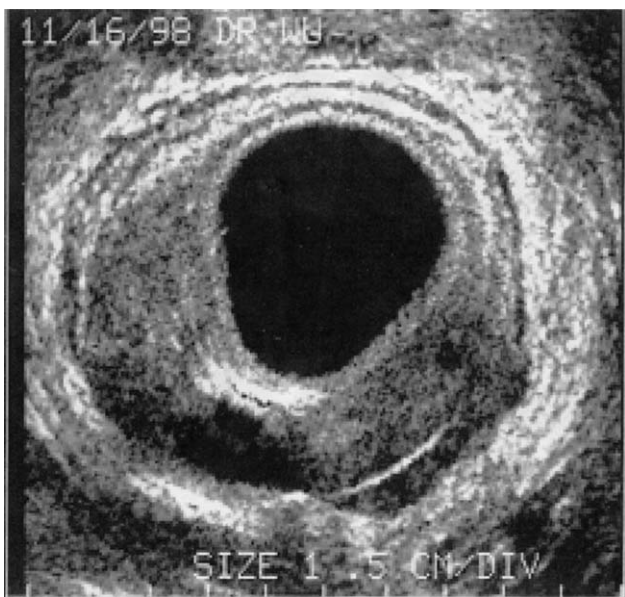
Transrectal ultrasound image of a low rectal cancer showing invasion through the submucosa. The outer border of the tumor is scalloped consistent with invasion through the muscularis propria. The ultrasonic stage is uT3N0.
